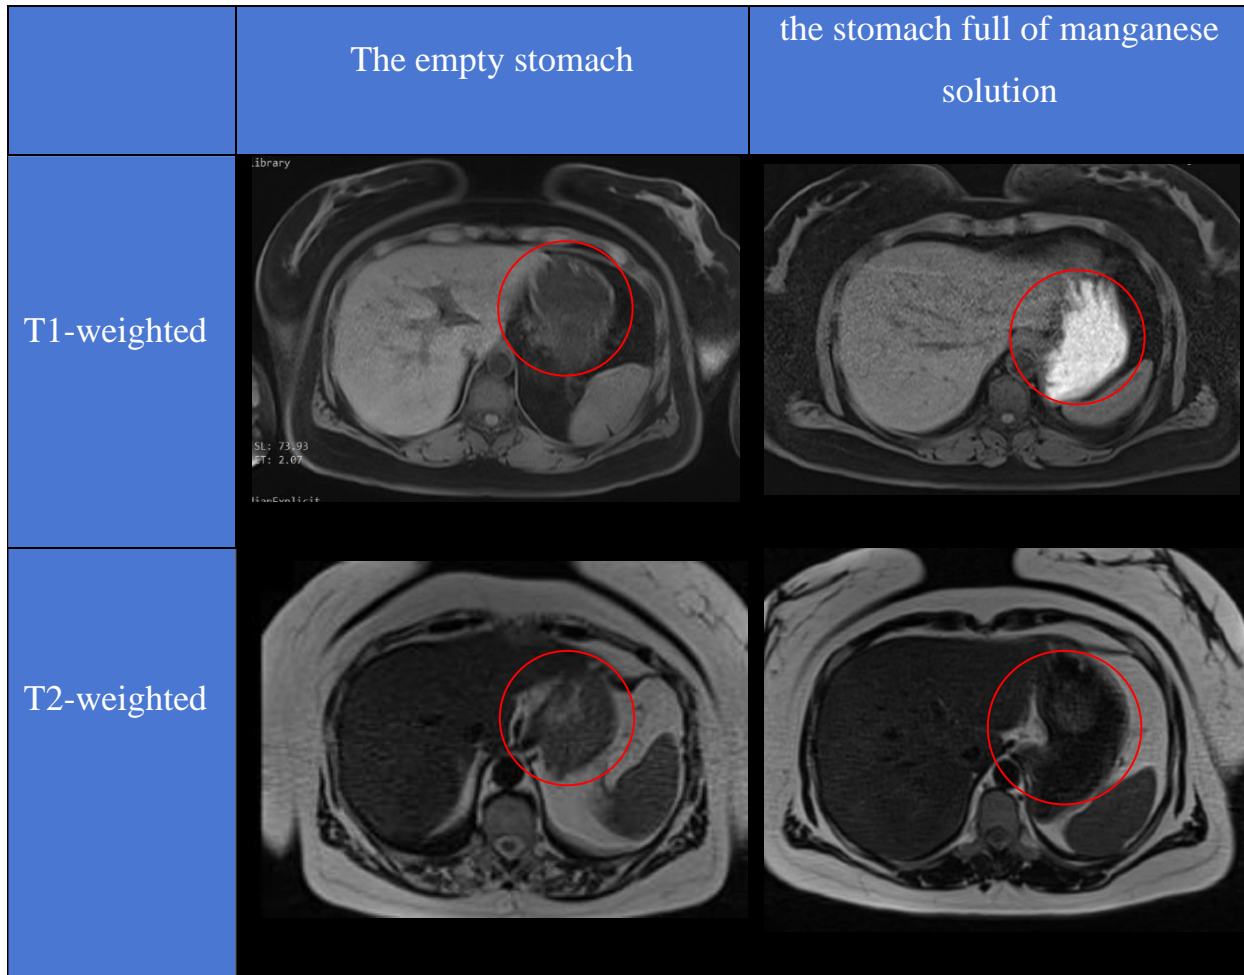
6: Transverse abdominal MRI for an empty stomach and a stomach full of manganese solution
